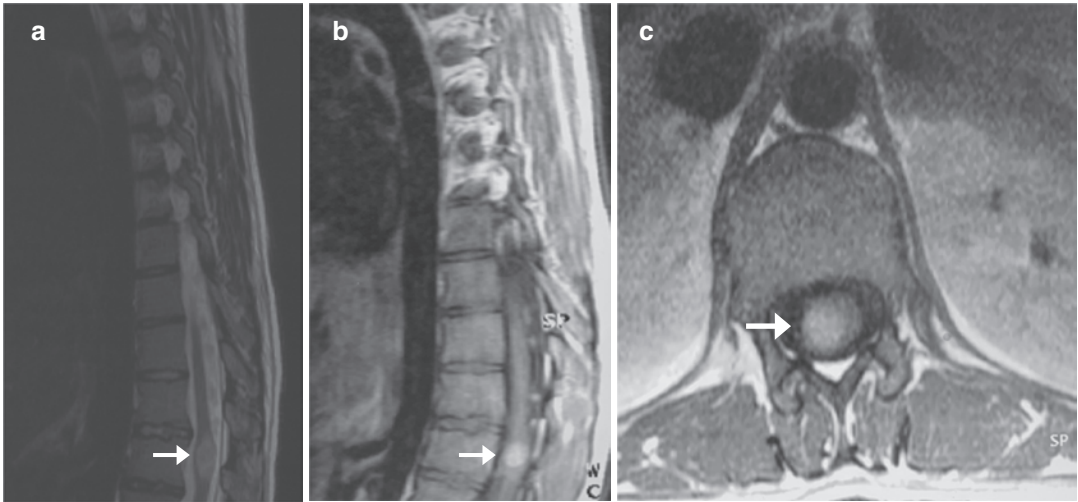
Spinal intramedullary tuberculoma. (a) Sagittal T2-W and (b) sagittal and (c) axial contrast-enhanced T1-W MR images show an intramedullary nodule (arrows)
